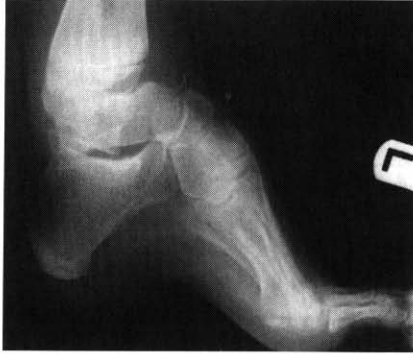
Weight-bearing lateral radiographic view with severe increase in calcaneal inclination angle.
